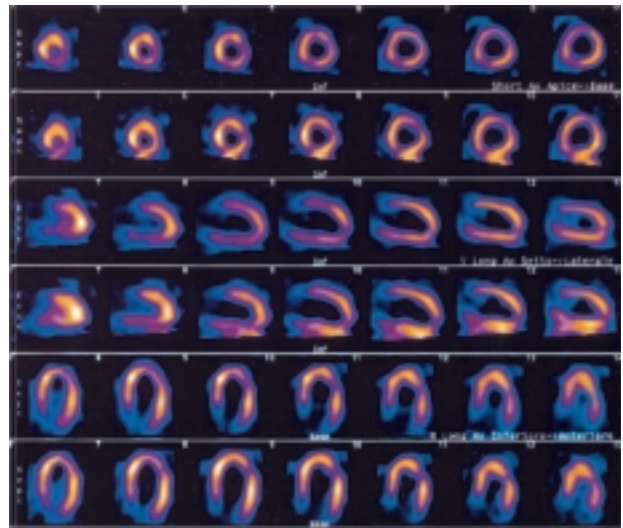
^{99m}Tc-MIBI SPECT myocardial scintigraphy at stress and at rest after the percutaneous coronary intervention and fistula closure.
